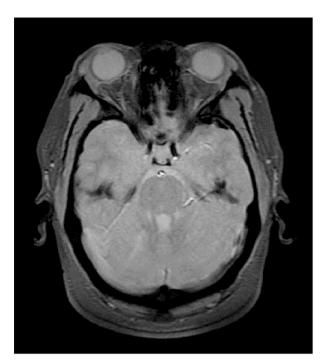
Axial T2-weighted brain MRI shows mild signal hyperintensity in right mediotemporal lobe.
